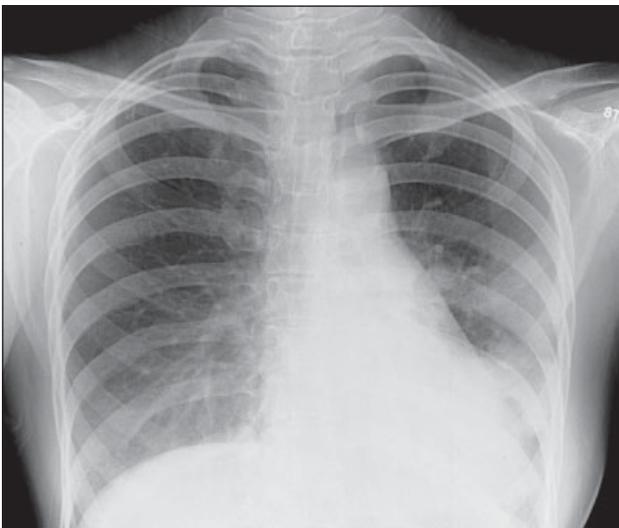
Frontal chest X-ray of a 23-year-old woman with severe acute respiratory syndrome showing ill-defined air space opacity in the lingular segment obscuring part of the left heart border. The initial chest X-ray 2 days previously was normal.
